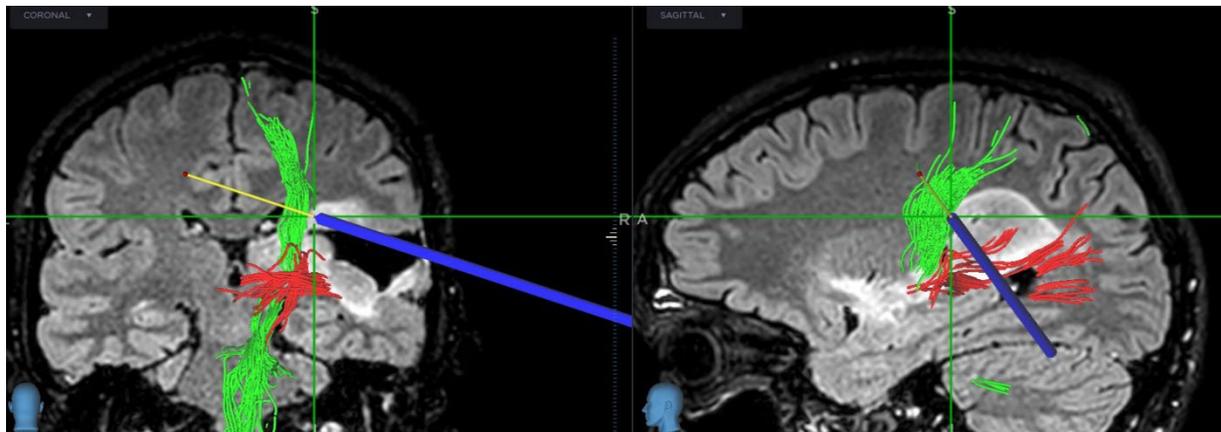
Intraoperative screenshot of the neuronavigational system. The figure shows a coronal (left) and sagittal image of a patient with a brain tumor (white areas). MRI and tractographic results (green = motor pathways) were acquired before surgery. Navigation is used for real-time localization of anatomical structures during surgery (based on preoperative images). A pointing device (blue line) indicates a site where electrical stimulation elicited motor movements in the patient (the yellow line represents a virtual extension of the probe). In this case, tractographic results and DES show good (qualitative) agreement.
